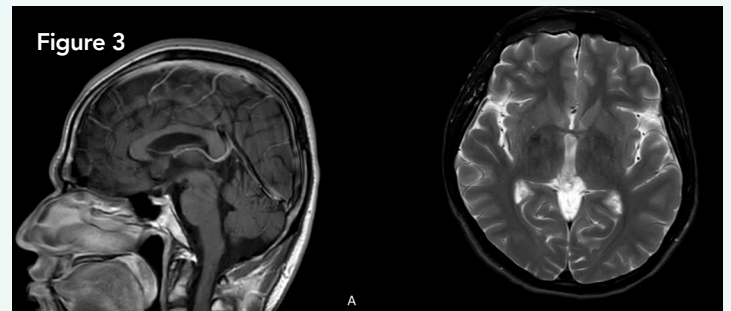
14-month follow-up MRI T1 with contrast subsequent to radiation therapy demonstrates absence of pineal germinoma (A). Axial T2 MRI demonstrates resolution of hydrocephalus (B).
